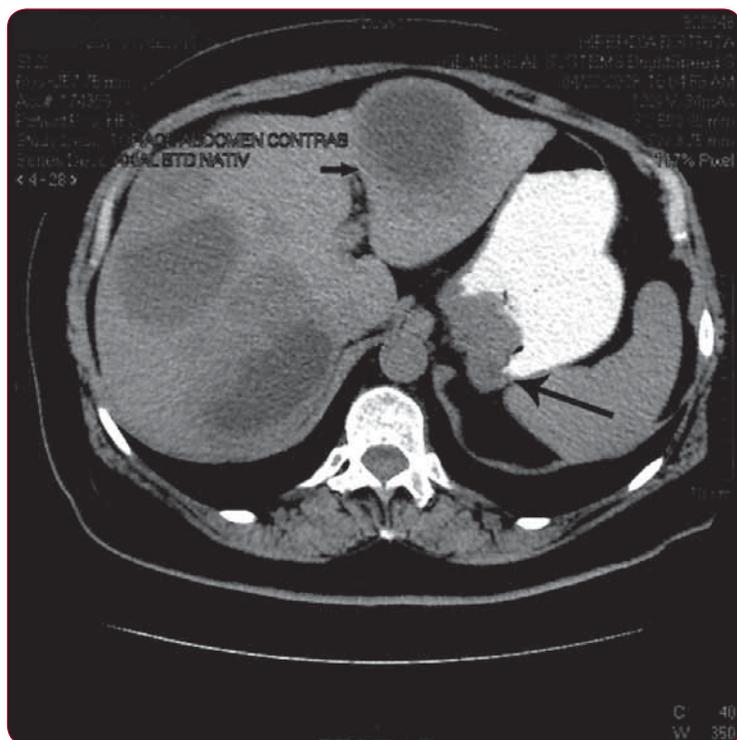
Computed tomography before starting the treatment. Multiple hepatic cysts with thick wall (small arrow) and a large gastric subcardial tumour (big arrow)
